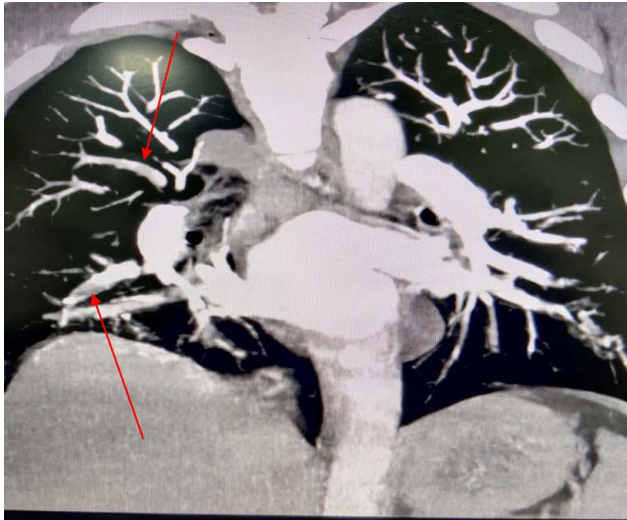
CT scan showing hypodense nonenhancing filling defect in right pulmonary artery. (red arrow).
